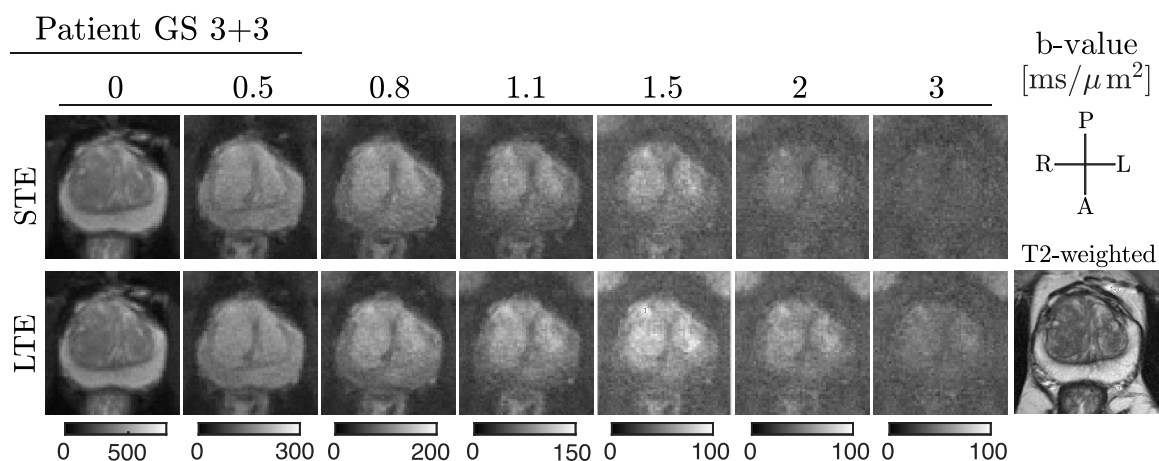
Overview of dMRI images acquired with LTE and STE - in rows - across wide range of b -values - in columns. For a comparison to an anatomical scan, a corresponding image slice of T2-weighted contrast is shown.
